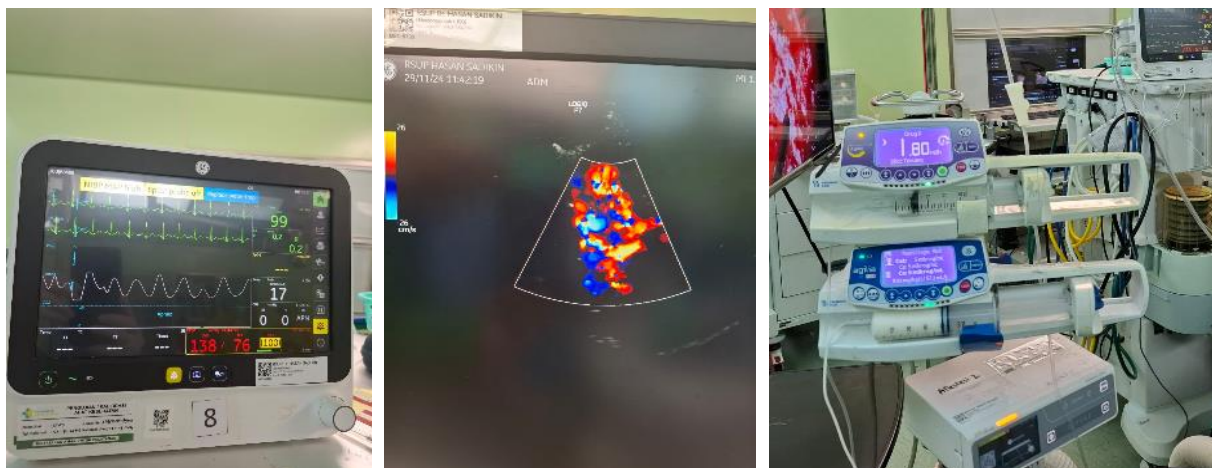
Preoperative hemodynamics, preoperative transcranial Doppler (TCD), maintenance TCI propofol and dexmedetomidine
